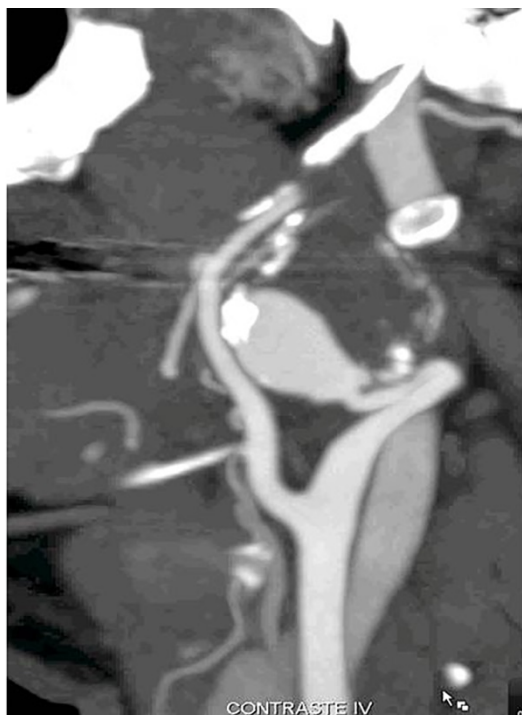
Angio- CT Scan: Lateral View of the right carotid axis
